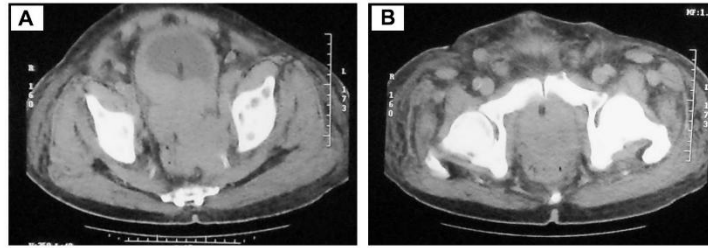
Panel A: Plain CT axial image showing giant prostate cancer infiltrating the anterior rectal wall
